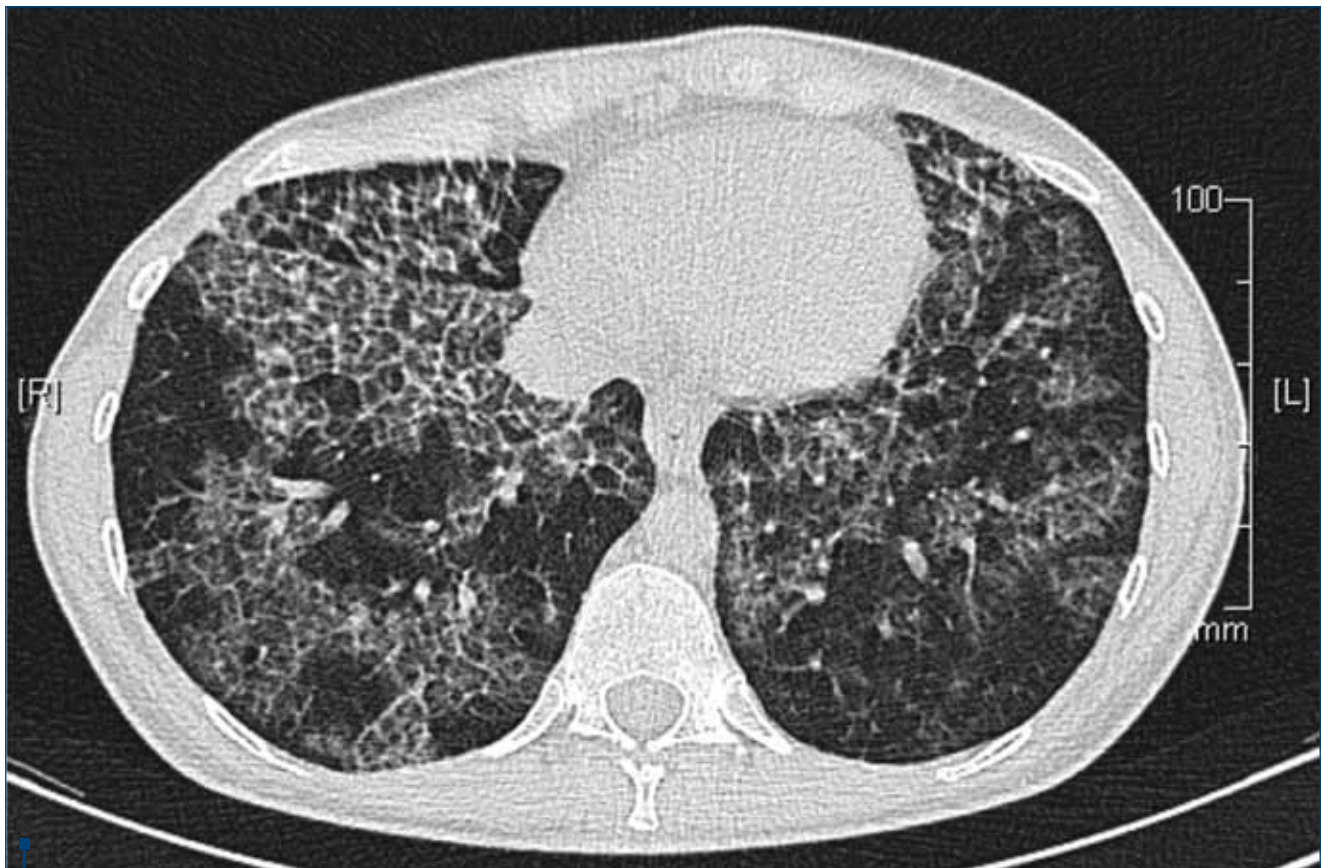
High resolution computed tomography of pulmonary alveolar proteinosis: characteristic "crazy paving" pattern in a "geographic" distribution.
